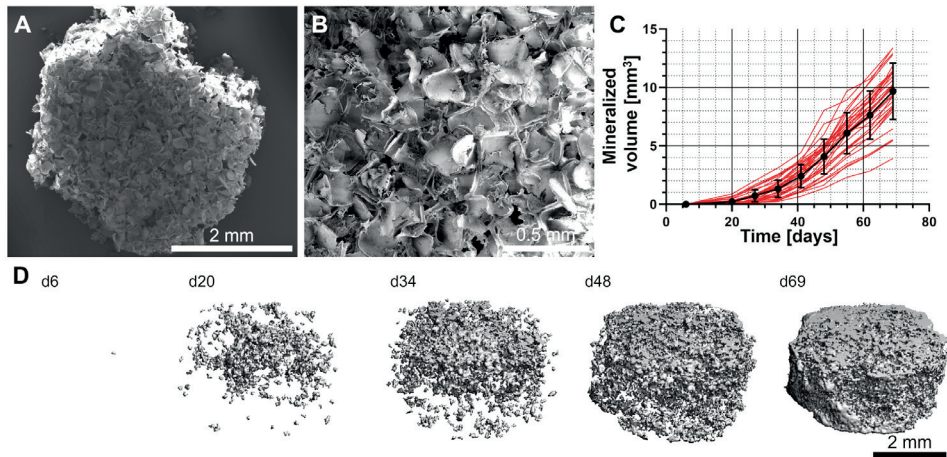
Mineralized matrix deposition over time onto SF scaffolds. (A) Top view of a freshly prepared SF scaffold. (B) Higher magnification view revealing the highly porous nature of the scaffolds. (C) μ CT monitoring confirmed continuous mineralized matrix deposition and an increase in mineralized volume during the entire culture duration. Individual construct volumes are shown in red; the mean \pm SD are shown in black. (D) The volumetric distribution and growth of an individual construct over time.
